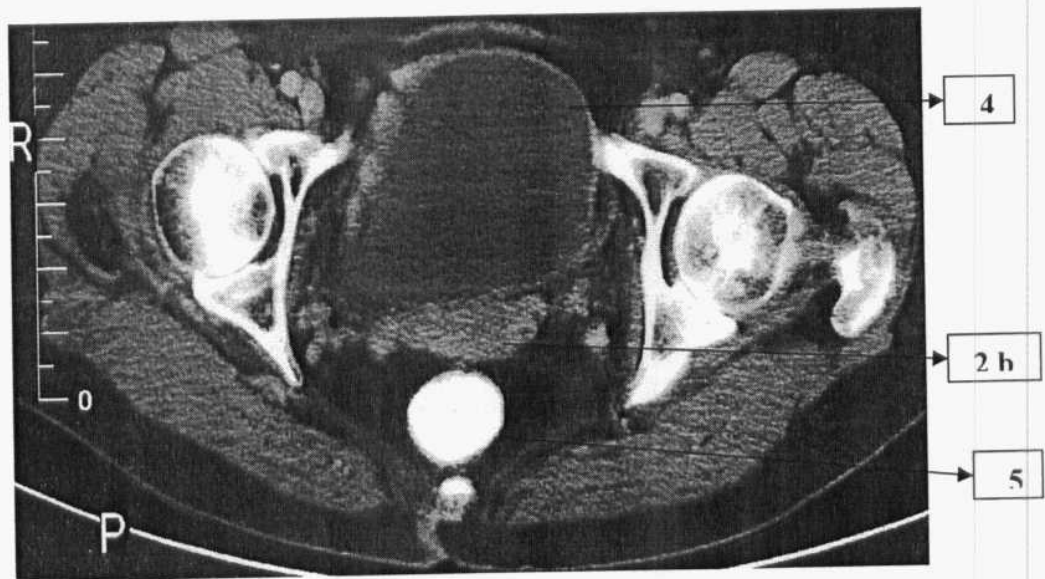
Axial CT of female pelvis
